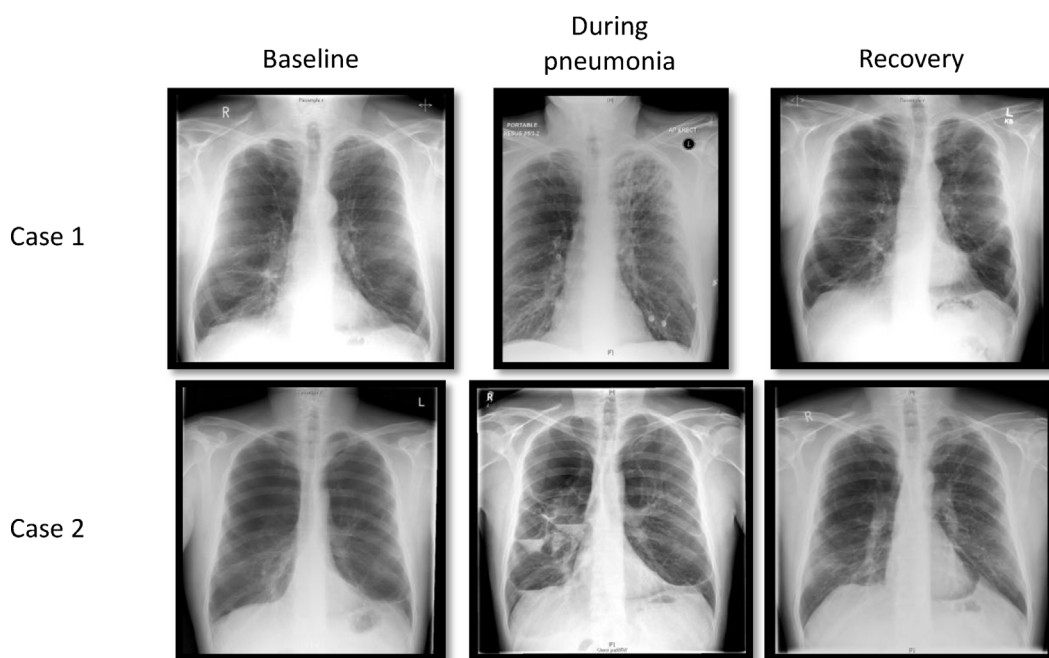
Chest plain radiographs for both cases showing pre-, during- and post-pneumonia radiology. Chest plain radiographs for both cases showing pre-, during- and post-pneumonia radiology. Case 1: During-pneumonia plain radiograph demonstrates left upper lobe consolidation superimposed upon emphysema. Mild resulting volume loss on the post pneumonia image, better demonstrated by CT imaging in Fig. 1. Case 2: Multiple air fluid levels within bilateral bulla in the upper zones, with a rounded opacity in the Left upper zone representing a large fluid filled bulla during-pneumonia imaging. Post pneumonia plain radiograph demonstrates volume loss in the left upper lobe as evidenced by superior retraction of the left hilum and tenting of the left hemidiaphragm.
